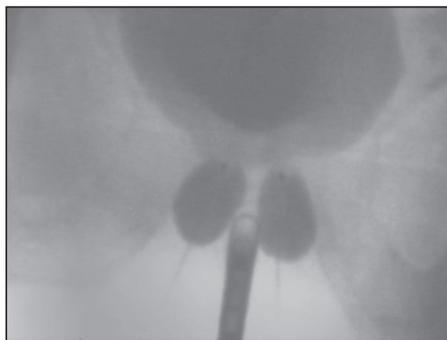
Image of Proper Device Positioning (X-ray)¹
